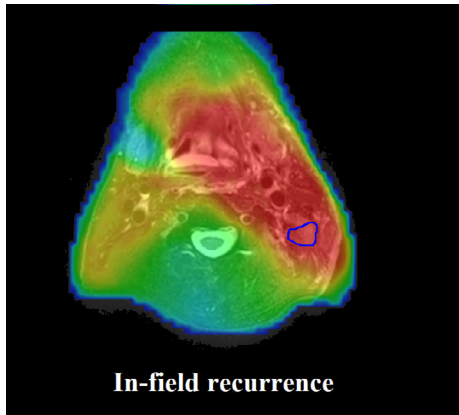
MR image of a patient with an in-field recurrence. The MR image made at the time of the recurrence is shown with an overlay of the dose map made during the treatment of the primary tumor. Dark blue areas represent a cumulative dose of 1 Gy, dark red areas represent a cumulative dose of 70 Gy. The dark blue circle indicates the location of the recurrence. The entire volume of recurrence was positioned inside the high dose area of the initial treatment. This suggests that the recurrence is an in-field recurrence.
